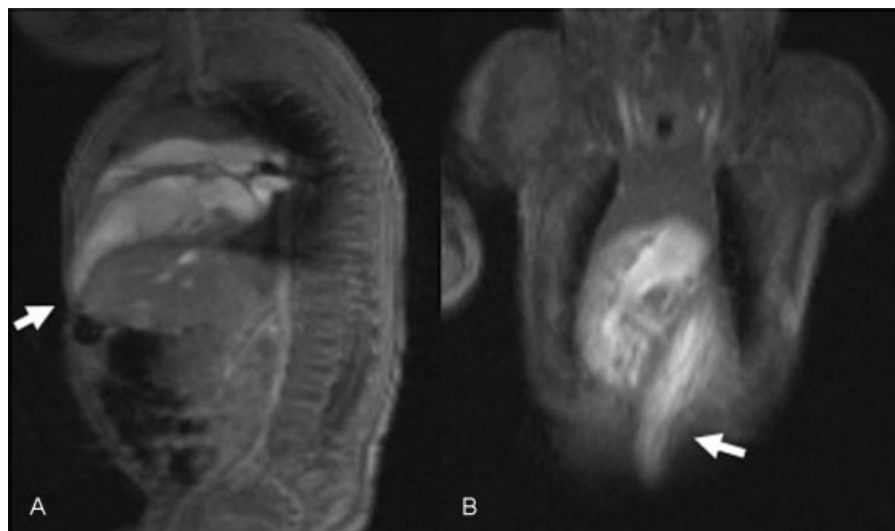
Magnetic resonance imaging at 2 months of life: left ventricular diverticulum (arrows) extending from the chest into the abdomen (two views: sagittal, A; coronary, B).
